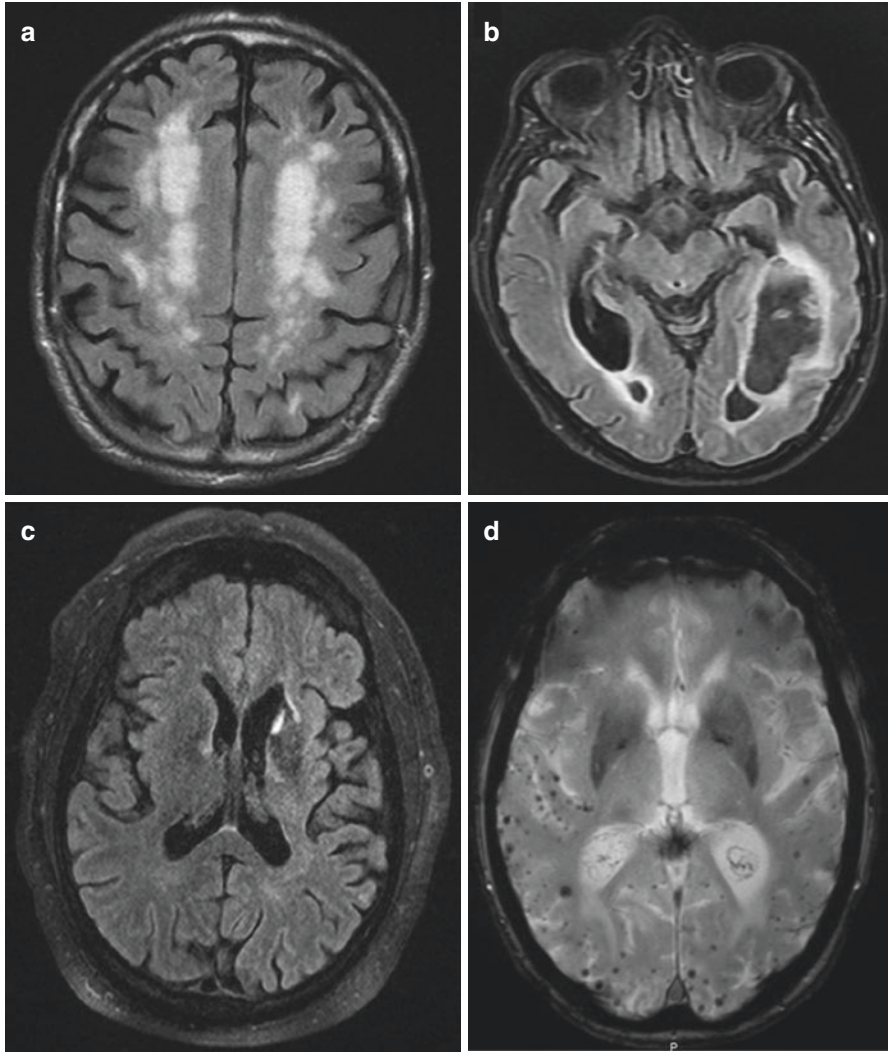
MRI findings in VaD. (a) Confluent white matter changes related to small vessel disease on FLAIR imaging sequence in a patient with Binswanger's disease. (b) Left temporal-parietal lobar hemorrhage with subsequent alexia as a striking cognitive deficit on FLAIR imaging sequence. (c) Left caudate infarct in a patient with strategic infarct dementia resulting in executive dysfunction following disruption of frontal subcortical circuits on FLAIR imaging sequence. (d) Multiple cortical microhemorrhages in a patient with cerebral amyloid angiopathy on a T2* sequence
